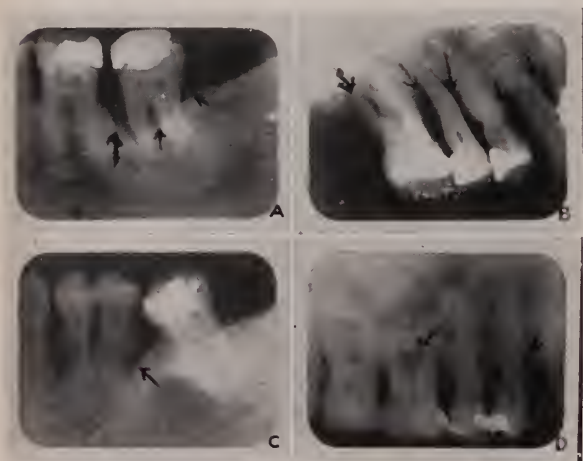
Roentgenograms showing deep pyorrhea pockets along the roots of teeth and between the bifurcations of molar teeth.
